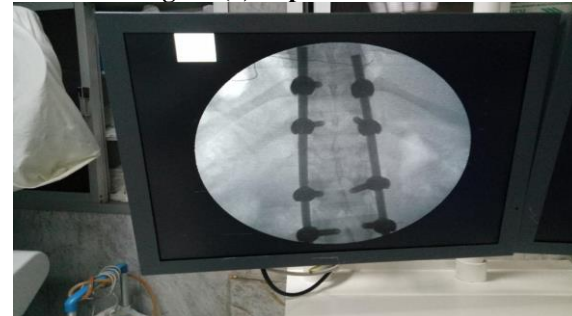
Postoperative radiographical images: anterior-posterior view (Percutaneous fixation)
